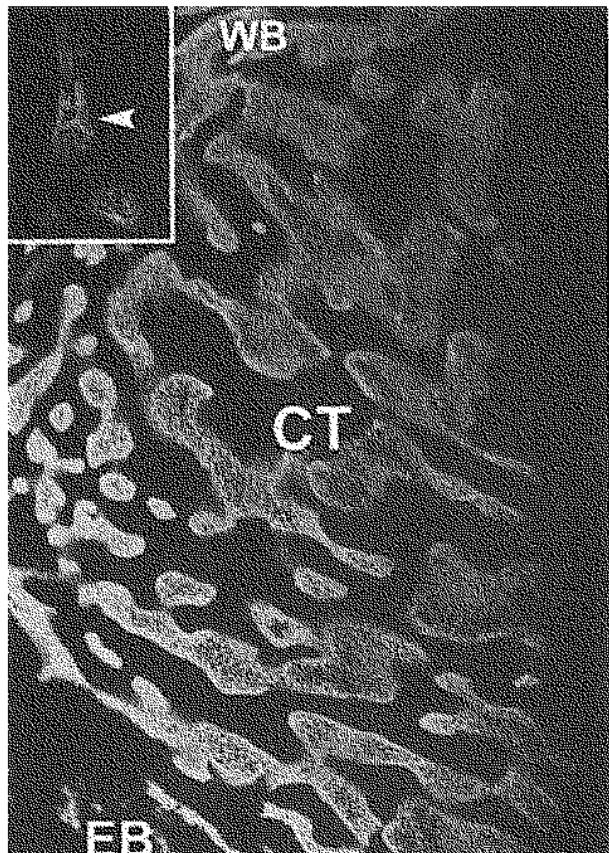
Oblique section through the triradiated cartilage. Left hip bone, 26 weeks of gestation. WB : Woven bone. CT : Chondroid Tissue, EB : Endochondral Bone (Microradiograph, $\times 43$).
